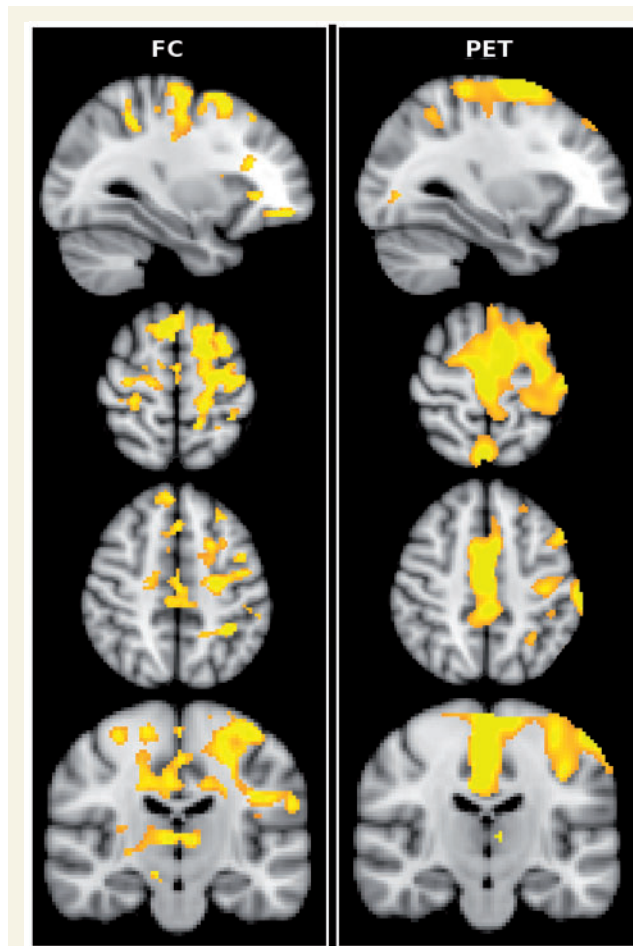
Regions of significant increase of functional connectivity and reduced GABA_A receptor ligand binding in two separate studies of patients with sporadic ALS. There is strong overlap in the spatial pattern between MRI and PET analyses although they were carried out on two different ALS patient populations (resting-state functional MRI data from this study shown on the left, and reductions in PET [11C]-flumazenil binding on the right adapted from Turner *et al.* (2005a)). Radiological convention, left is right. FC = functional connectivity.
